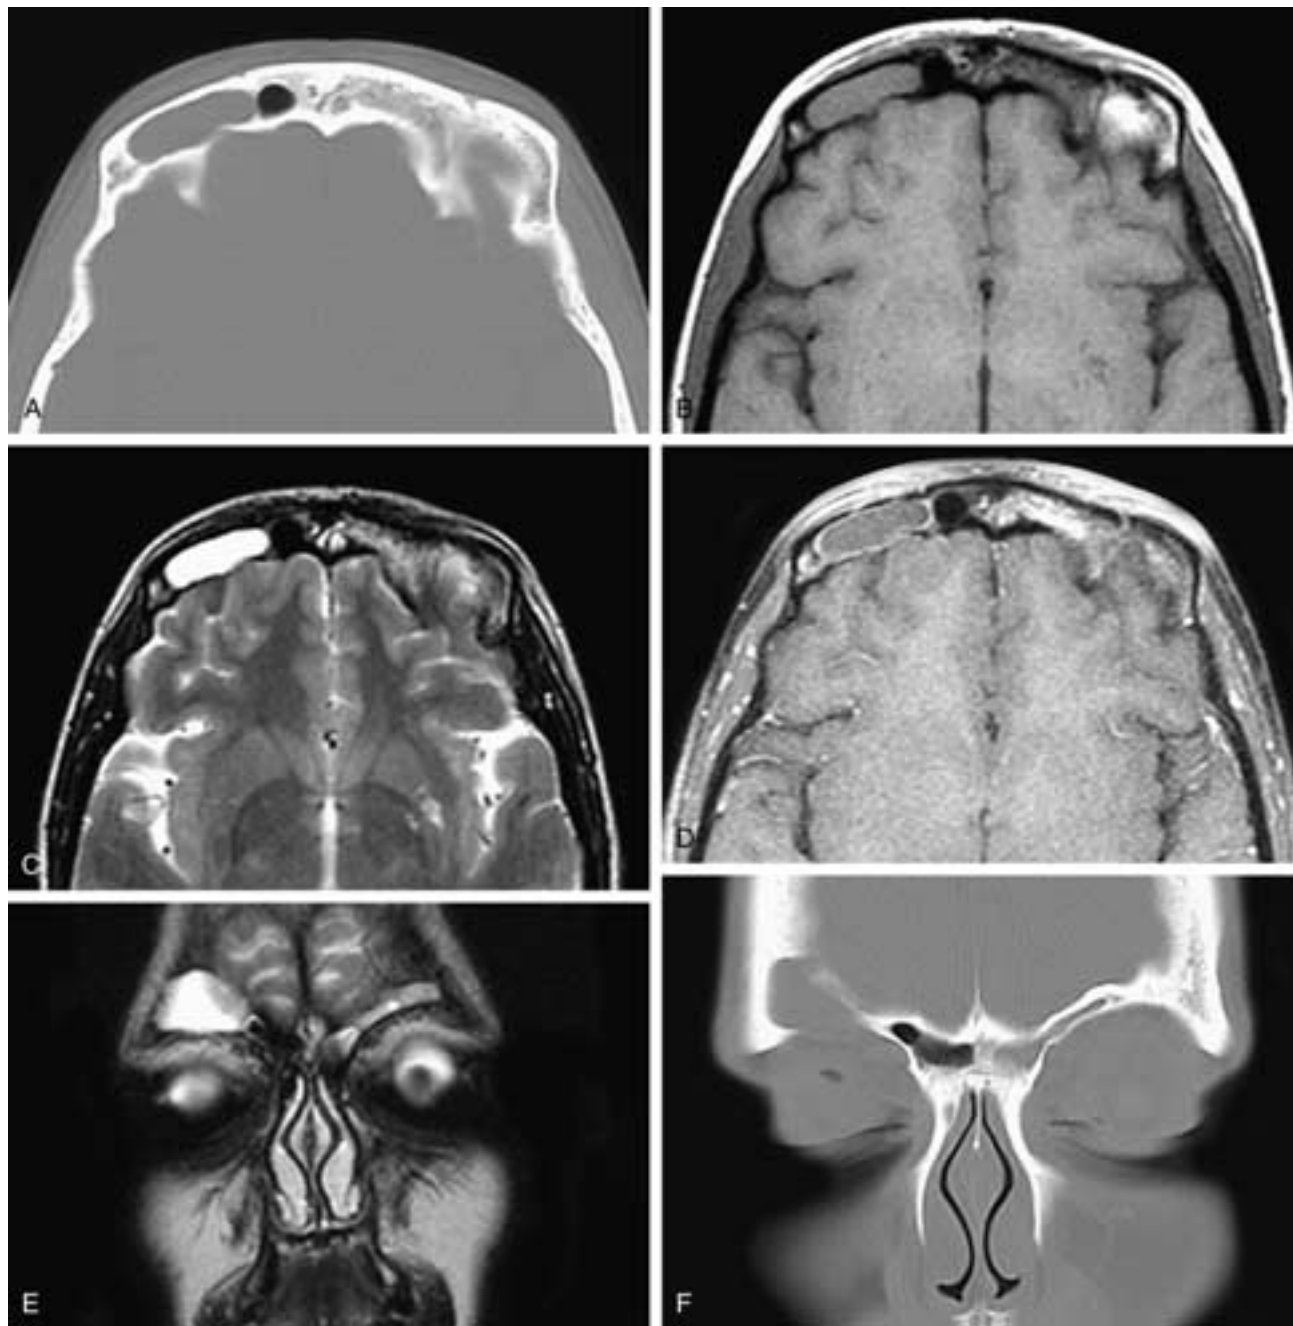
Axial CT scan (A) shows a smoothly margined mass in the right frontal bone. The medial aspect of the mass abuts on the right side of the right frontal sinus. Axial T1-weighted (B) and T2-weighted (C) MR images show the mass to have an intermediate T1-weighted and high T2-weighted signal intensity. Axial T1-weighted, fat-suppressed, contrast-enhanced MR image (D) shows some enhancement around the margins of the mass. Coronal T2-weighted (E) MR image and coronal CT scan (F) show that the mass is adjacent to the right frontal sinus and has broken down into the roof of the right orbit. There is also some inflammatory disease in the left supraorbital sinus. This patient had a cholesteatoma of the right frontal bone.
